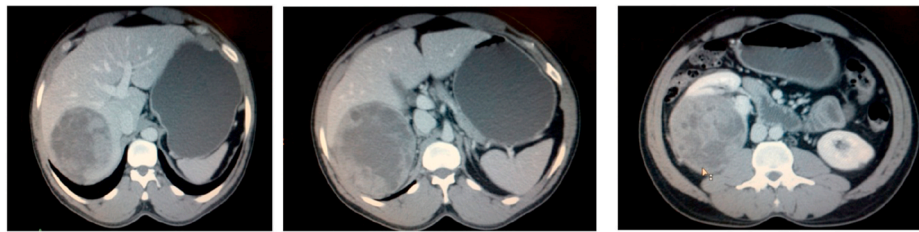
Contrast-enhanced CT scan of the abdomen, showing a large heterogeneously enhancing mass involving the upper pole and inter-polar region of the right kidney, which appears to infiltrate the right lobe of the liver.
